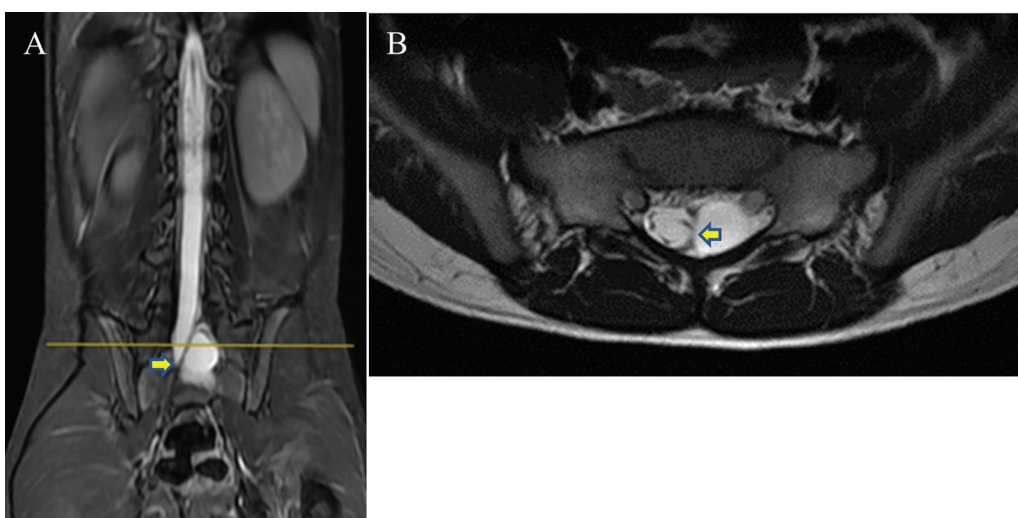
T2-weighted magnetic resonance imaging of the same patient in coronal (A) and axial (B) views. A clear interface between the two cysts. Note the displacement of the cord by the cyst in coronal view.
